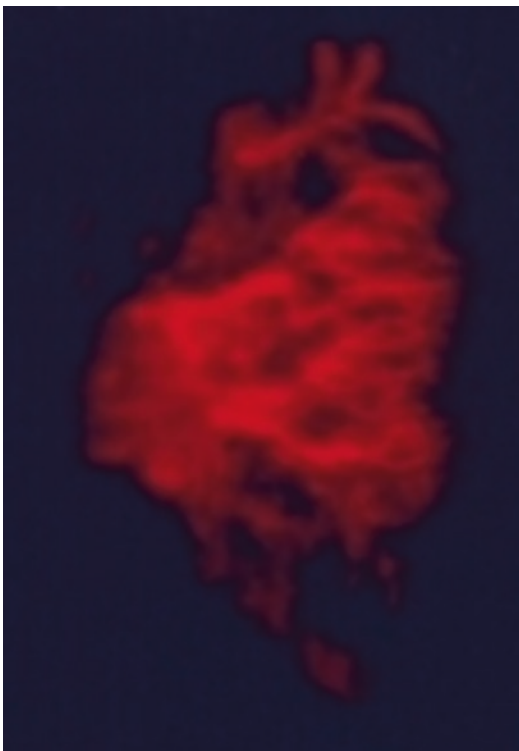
Doppler 3D image of the arterial vessels of the kidney
